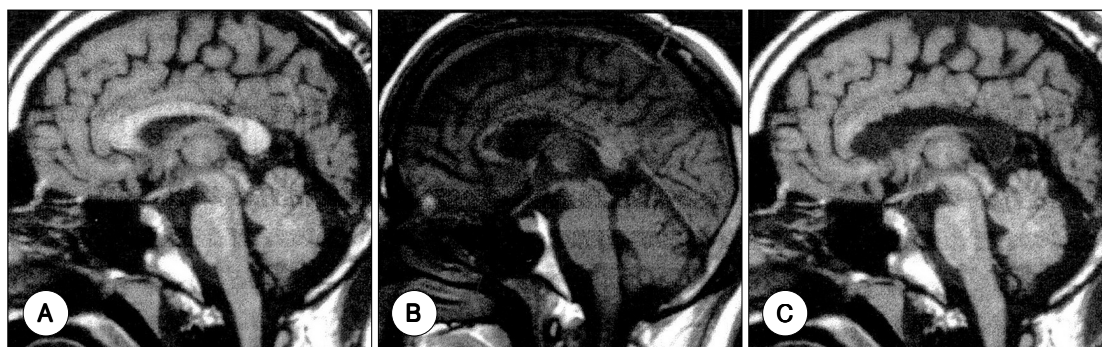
A : Preoperative sagittal view of MR images of 21 years-old women with frequent drop attacks associated with generalized tonic-clonic seizure. B : Follow-up MRI 6 months after anterior callosotomy. The frequency of drop attacks was decreased but persisted. She underwent total callosotomy. C : MRI revealing totally resected corpus callosum.
